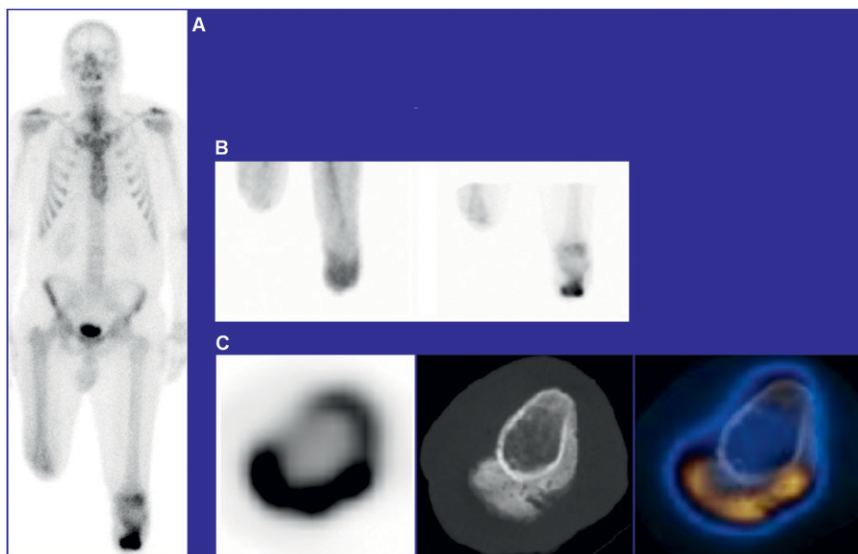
Bilateral amputations, bone vs. soft tissue infection. Left: Whole-body imaging. Top: Blood pool (left) and delayed (right) imaging. Bottom: SPECT (left); CT (middle); fused (right) images showing uptake corresponding to heterotrophic ossification.
